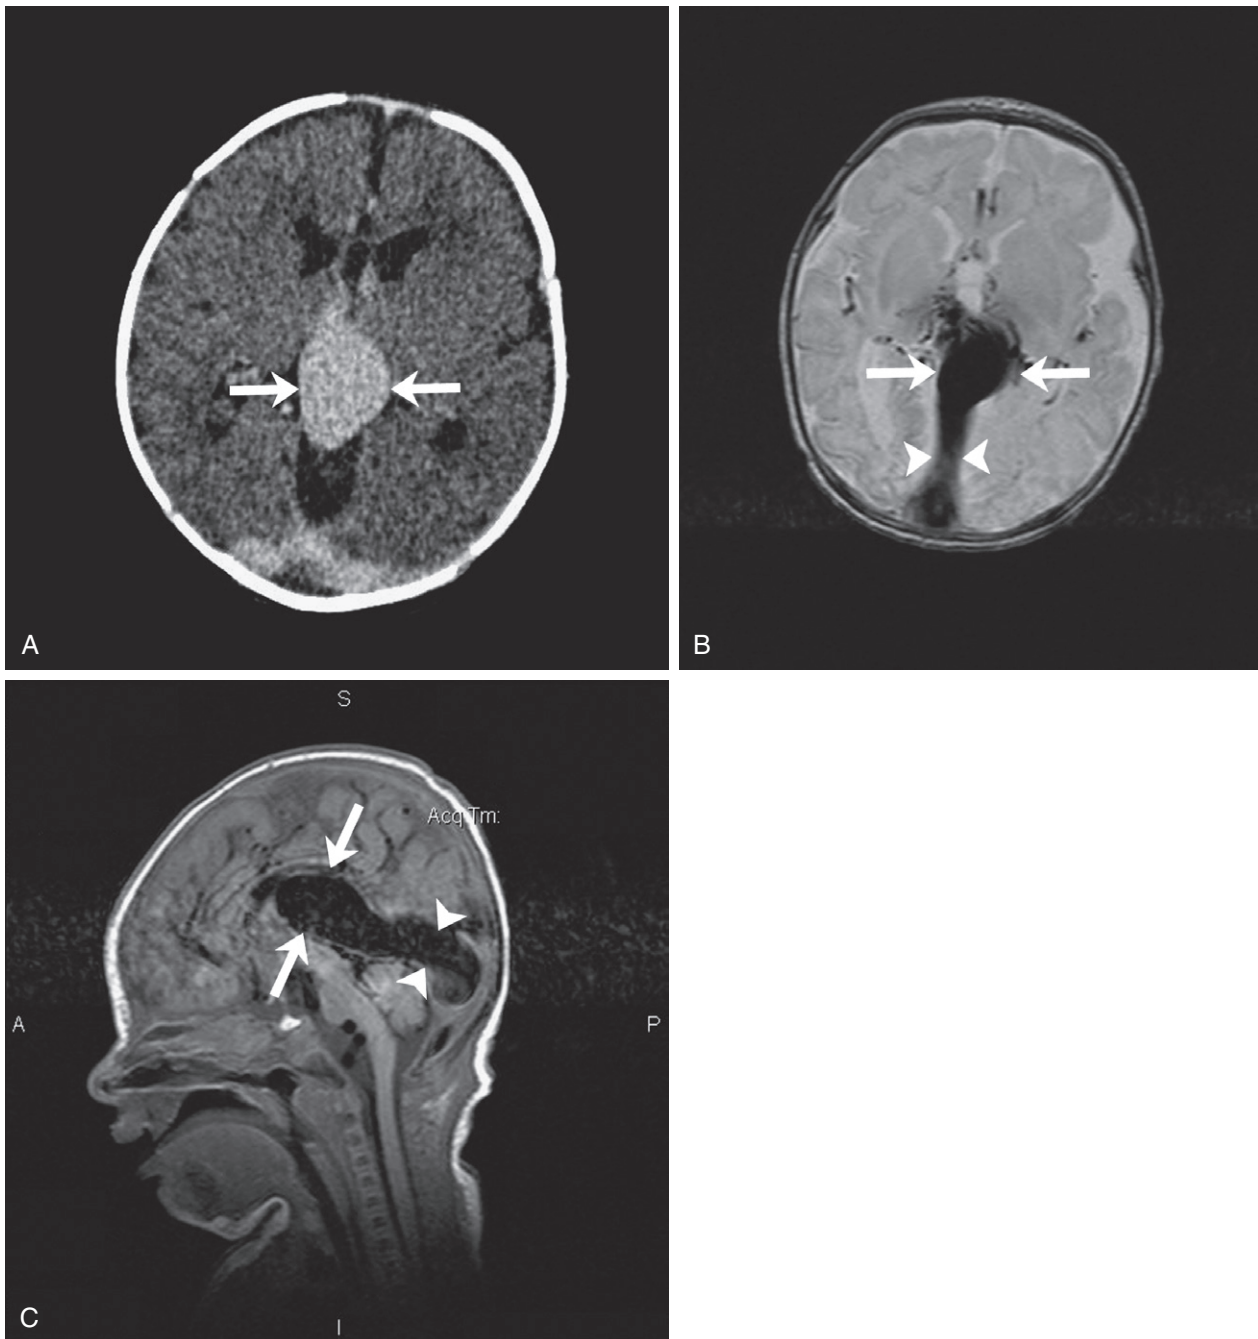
Vein of Galen aneurysmal malformation (VGAM). A, Axial noncontrast CT shows the dilated embryonic vein (*arrows*). Axial T2 (B) and sagittal T1 (C) MRI demonstrates the dilated embryonic vein (*arrows*) and the draining vein (*arrowheads*).
